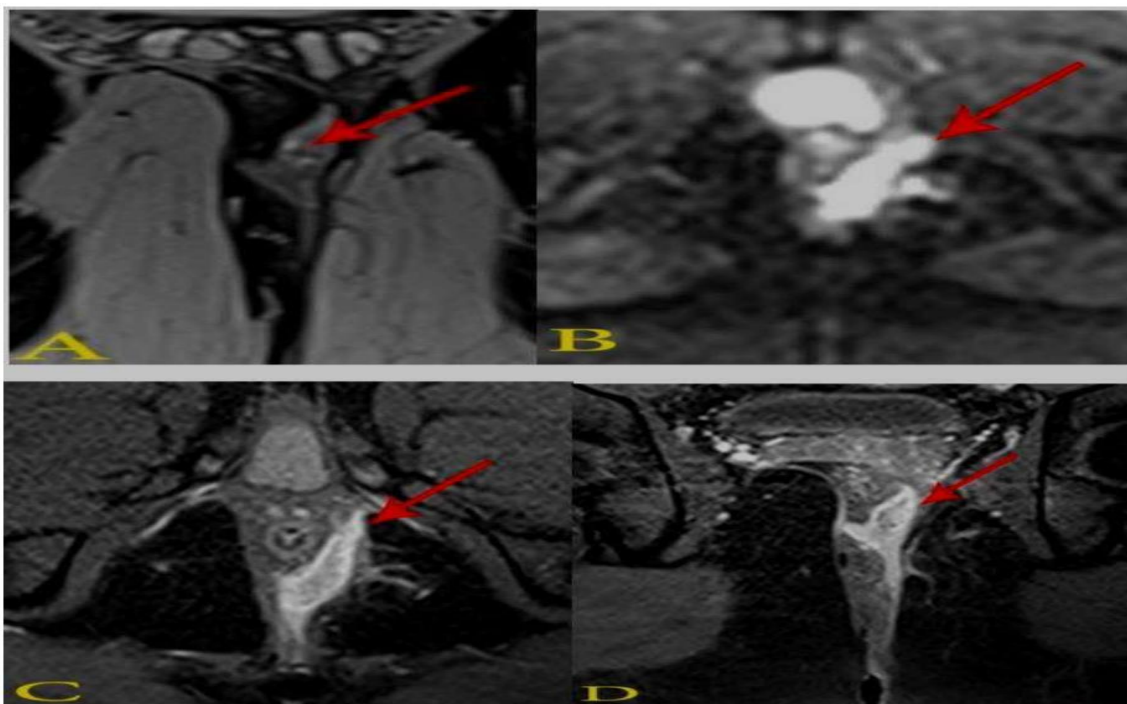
A male patient aged 52 years old complaining of pain, perianal discharge. (A) Coronal T2-WI: shows fistula tract (hyper-intense) from left natal cleft with intersphincteric collection and supralelevator extension (arrow).(B) Axial DWI: shows restricted diffusion (hyper-intensity) of the collection (arrow).(C,D) Axial and sagittal fat-suppressed T1+C: enhanced fistulous tract from left natal cleft, tract traverses with large intersphincteric abscess (arrow) with supralelevator extension (arrow in D).Overall MRI finding consistent with perianal fistula with supralelevator extension (Grade V).
